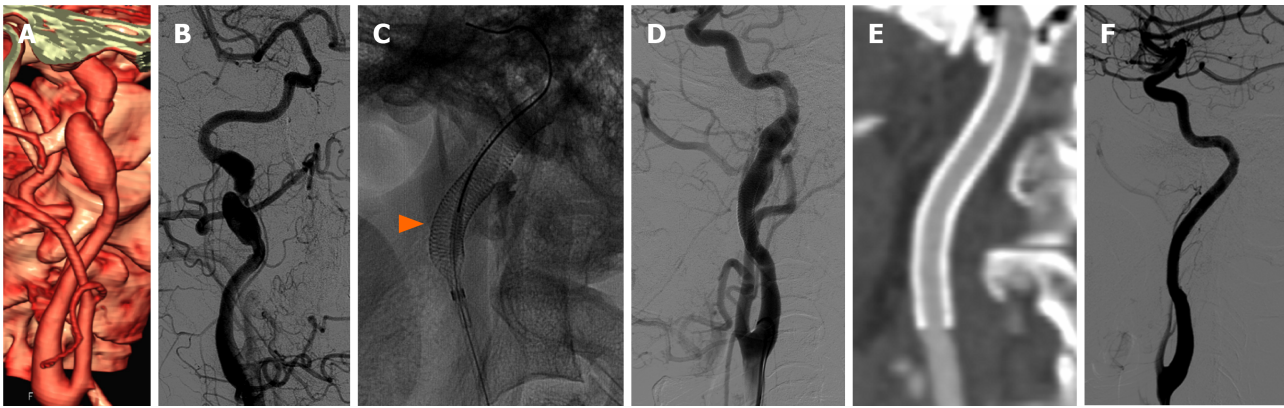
Case 2 was a 57-year-old man who suddenly felt dizzy and developed unsteady walking in November 2019. He was ultimately treated using a SUPERA stents. A: Cervical computed tomographic angiography (CTA) volume reconstruction; B: digital subtraction angiography (DSA) showed a fusiform dilated dissecting aneurysm with severe stenosis located in the upper segment of the right internal carotid artery, involving the petrous segment; C and D: It was treated with SUPERA stent endovascular treatment, the arrow shows the dense stent reticular wire; E: Three months later, cervical CTA showed that the aneurysm had disappeared completely, and the lumen of the internal carotid artery was unobstructed; F: One year later, DSA showed that the internal carotid artery was repaired perfectly.
